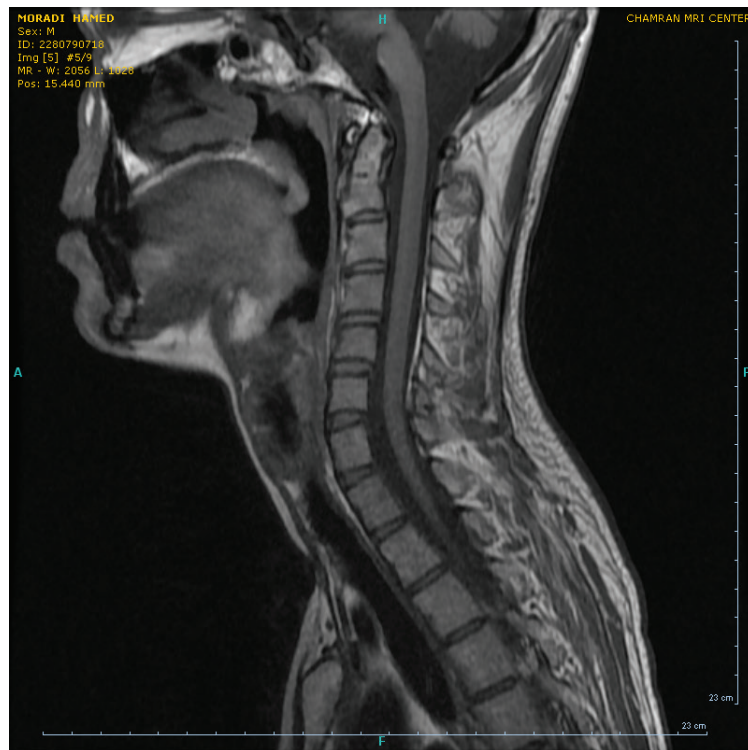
Sagittal cervical spinal cord T1-weighted MRI demonstrating no syringomyelia.
